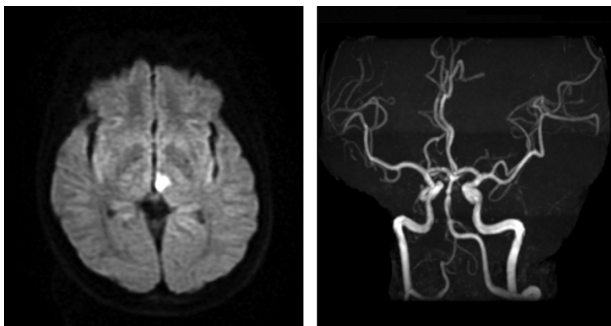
MR images (Diffusion image) revealed small infarction at the posteromedial of left thalamus (left) and MR angiography demonstrated dissecting aneurysm of basilar artery (right).
